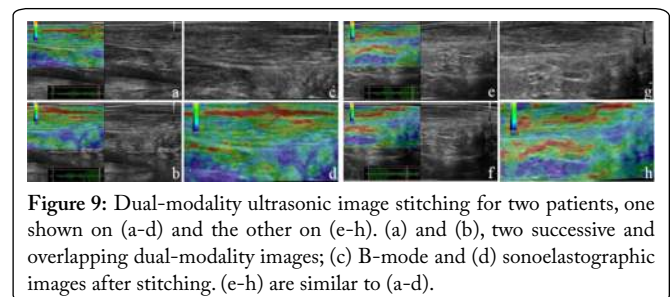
Dual-modality ultrasonic image stitching for two patients, one shown on (a-d) and the other on (e-h). (a) and (b), two successive and overlapping dual-modality images; (c) B-mode and (d) sonoelastographic images after stitching. (e-h) are similar to (a-d).
